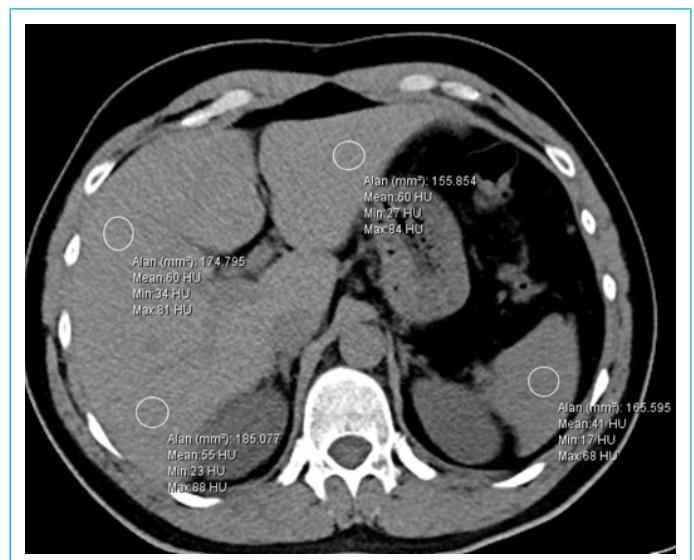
Representative unenhanced CT image showing the placement of regions of interest (ROIs) for the assessment of liver and spleen attenuation values (Hounsfield Unit).
